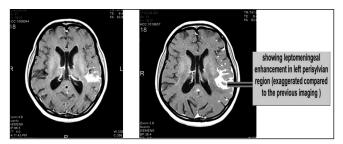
Follow-up MRI showed new tuberculoma and exaggerated leptomeningeal enhancement in the left temporal region.
